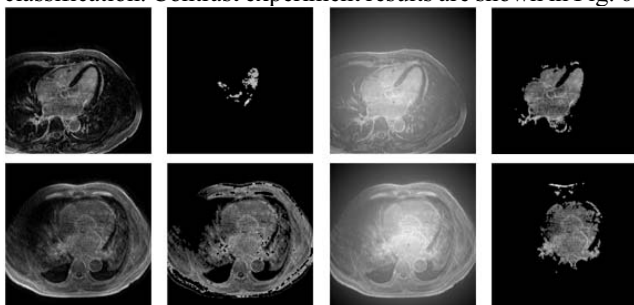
Extraction result of raw DE-MRI and enhanced DE-MRI. The left column are the raw DE-MRI and middle left column are the heart extracted from raw DE-MRI. The middle right column are enhance DE-MRI and the right column are the heart extracted from enhance DE-MRI.
